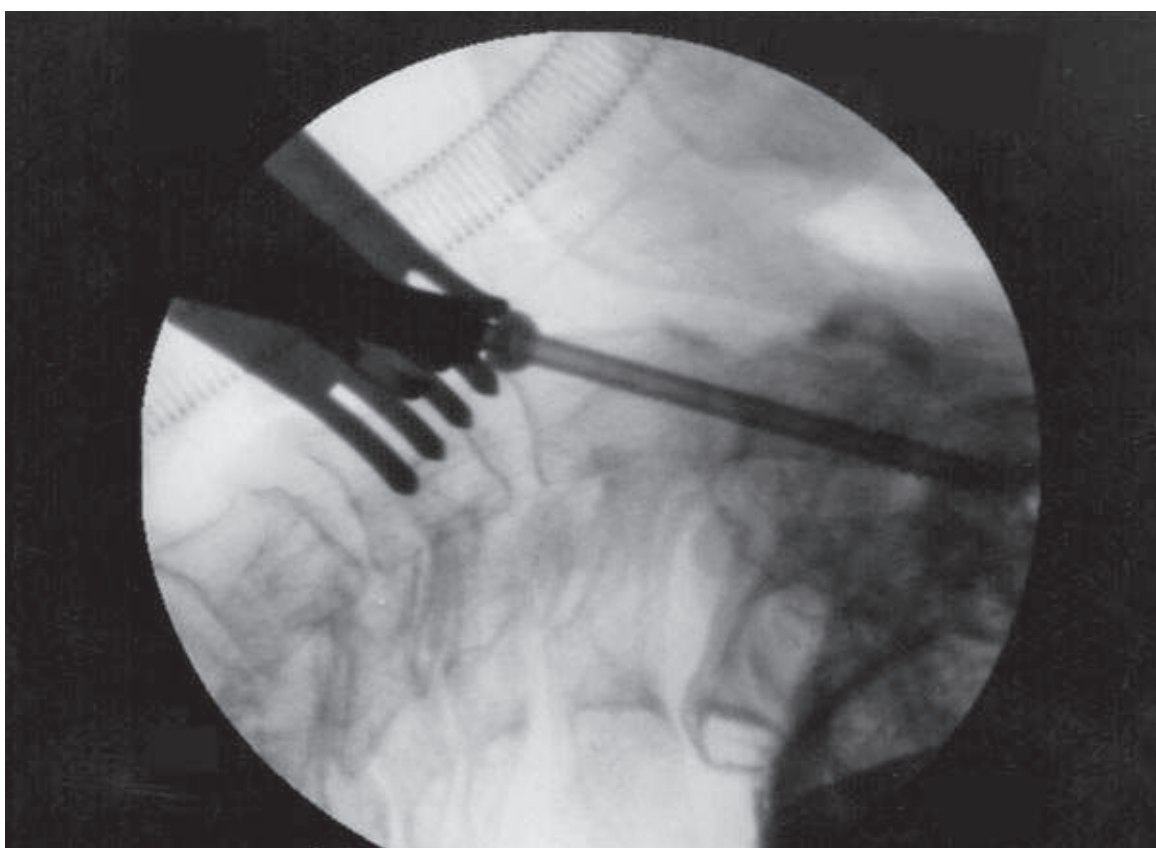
Lateral radiograph showing the final tightening of the cannulated, partially threaded, cancellous screw across the fracture site.
